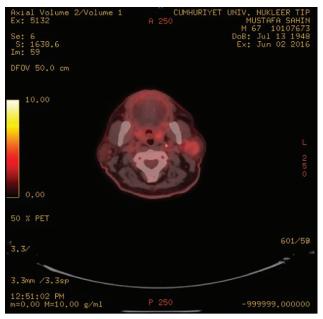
PET-CT image of the parotis mass.
